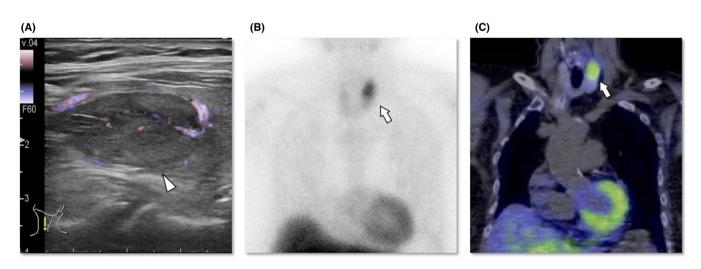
Representative radiologic findings of PHPT. Findings of cervical ultrasound with blood flow assessment (A, arrowhead), <sup>99m</sup>Tcsestamibi nuclear scintigraphy (B, arrow), and single photon emission computed tomography/computed tomography (C, arrow) are shown. PHPT: primary hyperparathyroidism
